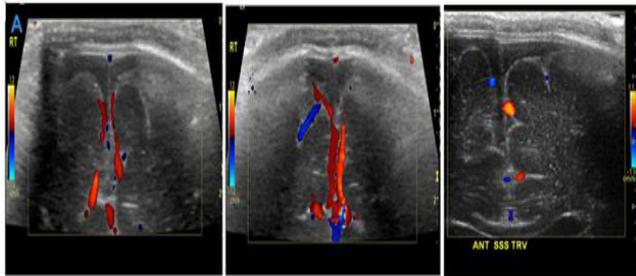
Small caliber of anterior segment of superior sagittal sinus with grading attenuation of color Doppler flow from anterior to posterior.
